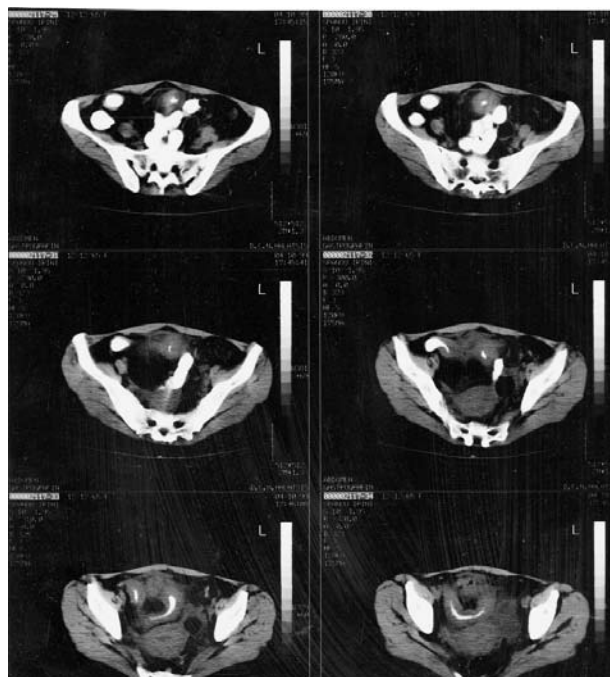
Computed tomography abdominal scan showing considerable thickness of the bowel wall of the terminal ileum accompanied by dullness of the mesenteric fat compatible with Crohn's disease. Fibrous elements and dullness of the pericystic fat in the posterior-lateral right wall of the bladder are clearly visible due to the presence of adhesions and fixation of a terminal ileum loop on the wall of the bladder.
